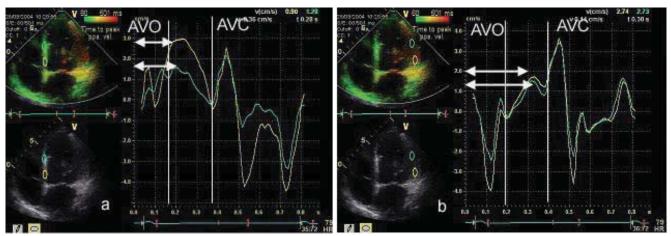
Method of measuring time to peak velocity from tissue Doppler graphs. (a) The regions of interest are placed on the septal wall at a basal and mid wall level and with the timing from QRS duration to peak systolic velocity. (b) This is repeated for the lateral wall. Note that all peak systolic velocities occurring after aortic valve closure are ignored.
